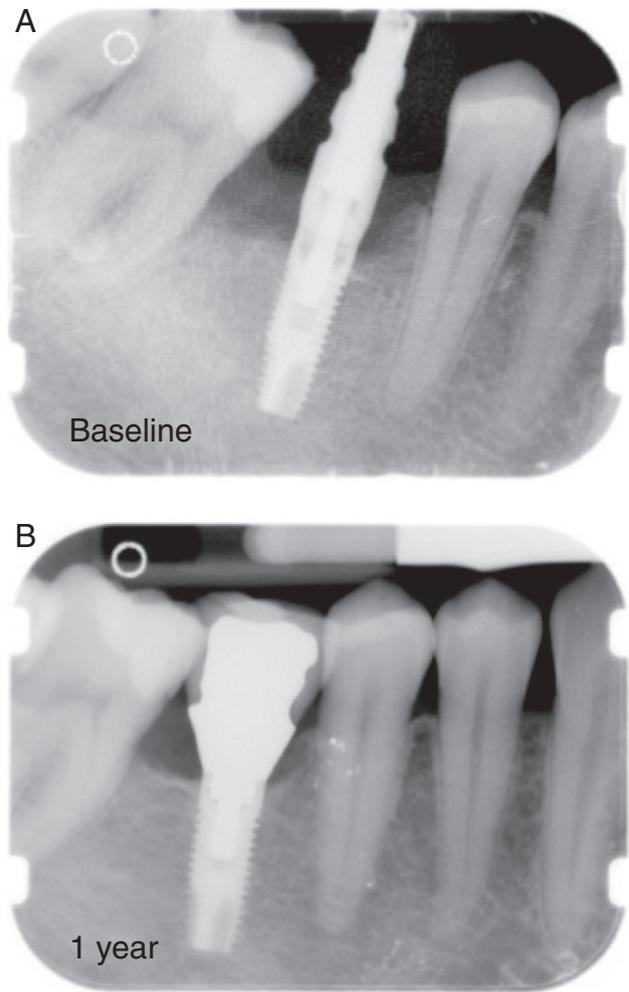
A, Radiograph demonstrating single NEOSS implant installed in the mandible at the time of impression (*baseline*). B, Single tooth restoration after 1 year in clinical function. Note stable marginal bone levels.
